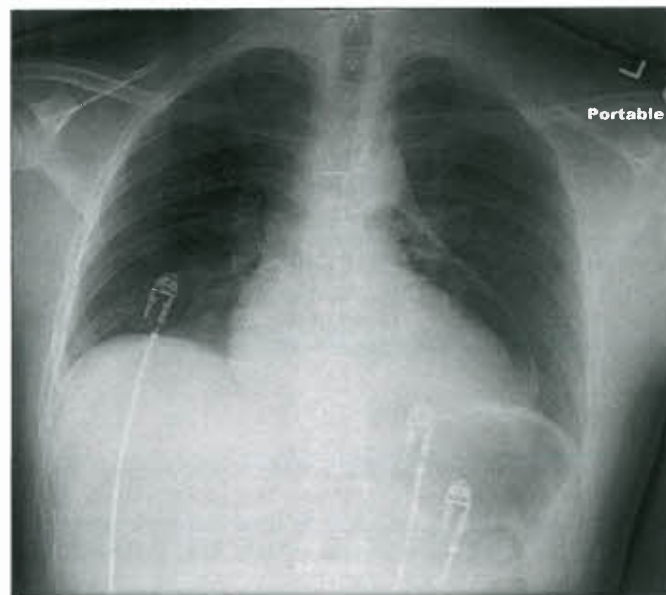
Chest radiograph of an adolescent patient who presented with chest pain after an esophagogastroduodenoscopy procedure. Perforation of the esophagus had occurred, with resultant pneumopericardium evident. (Courtesy of Dr. Malek El-Yaman, West Virginia University Children's Hospital, Morgantown, WV.)
